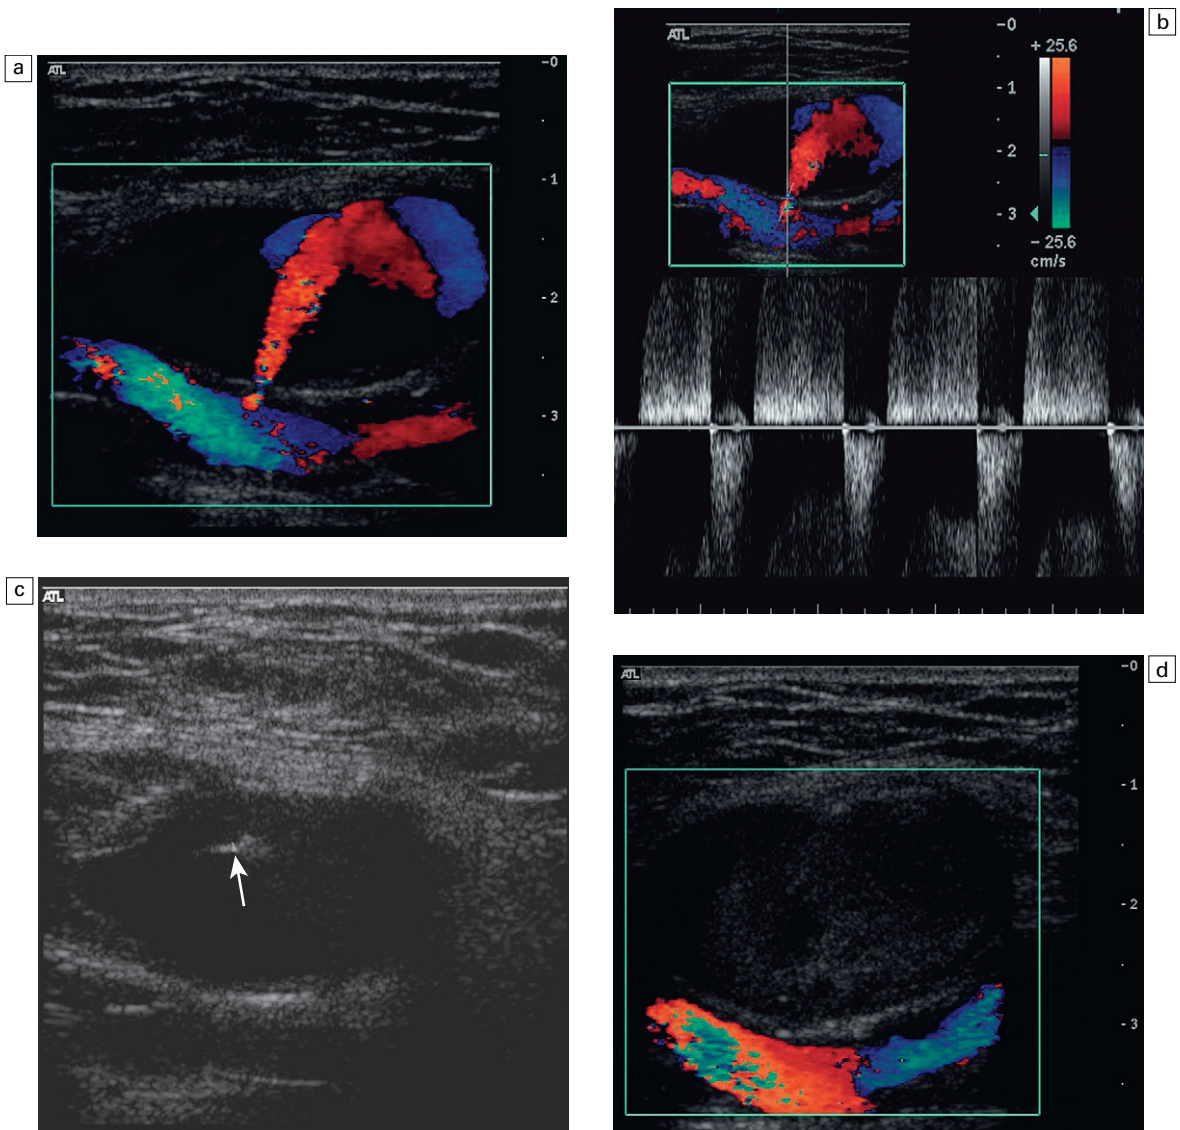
(a) A false aneurysm showing a patent lumen on colour Doppler; (b) the characteristic 'to-and-fro' flow on spectral Doppler; (c) tip of the needle for thrombin injection seen within the false aneurysm; (d) thrombosed false aneurysm following treatment with thrombin.
